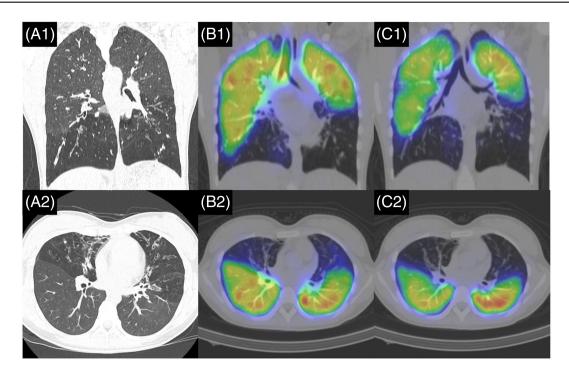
Findings from single photon emission computed tomography (SPECT)/computed tomography (CT). (A-1, 2) CT shows bronchial wall thickening and bronchiectasis, with emphysematous changes predominantly in bilateral lower lobes and the right middle and left upper lobes. (B-1, 2) SPECT/CT images of lung ventilation shows ventilation defects in bilateral lower lobes and the right middle and left upper lobes. (C-1, 2) SPECT/CT images of lung perfusion shows perfusion defects in bilateral lower, right middle, and left upper lobes. In particular, lung perfusion SPECT/CT showed markedly decreased perfusion in the lower lung fields.
